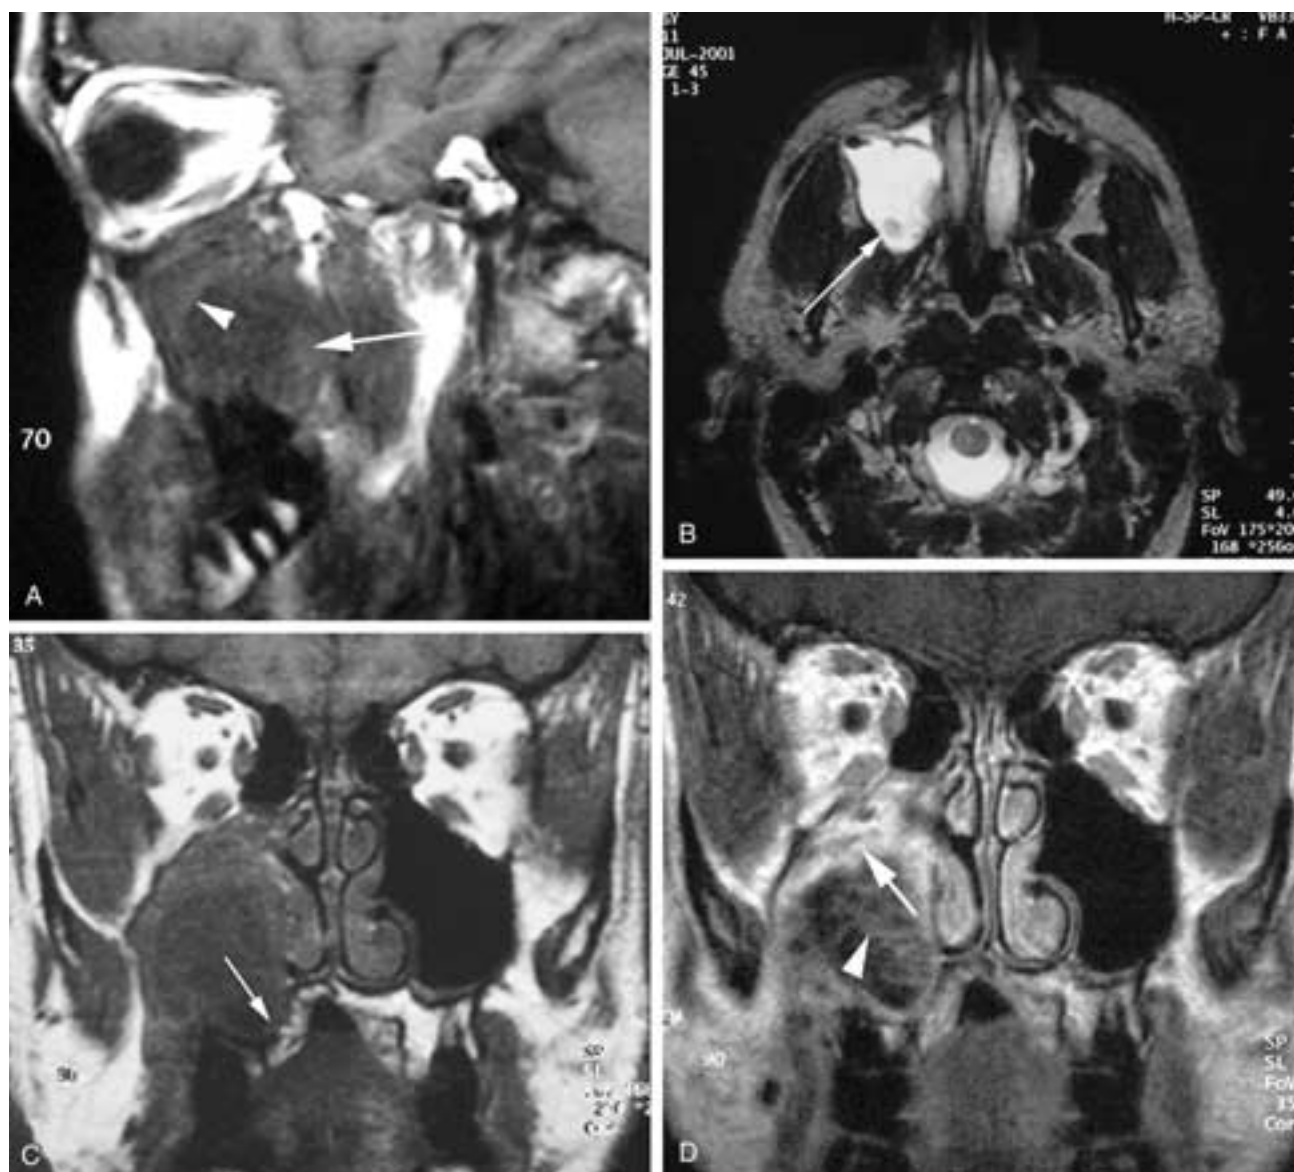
Ameloblastoma of the maxilla. A, Sagittal T1-weighted image shows an expansile lesion extending into the maxillary sinus. The superior margin of the lesion (*arrowhead*) extends into this sinus. An area of slightly higher signal (*arrow*) is a more nodular tissue extending into the primarily cystic abnormality. B, Axial T2-weighted image. The soft-tissue nodule (*arrow*) has lower signal than most of the cystic fluid. C, Coronal T1-weighted image. The lesion expands the palate and the alveolar process (*arrow*). D, Postcoronal T1-weighted image shows the nodular enhancement (*arrow*) along the margin. There is also an enhancing septation (*arrowhead*) within the lesion. Compare this to the pregadolinium image.
